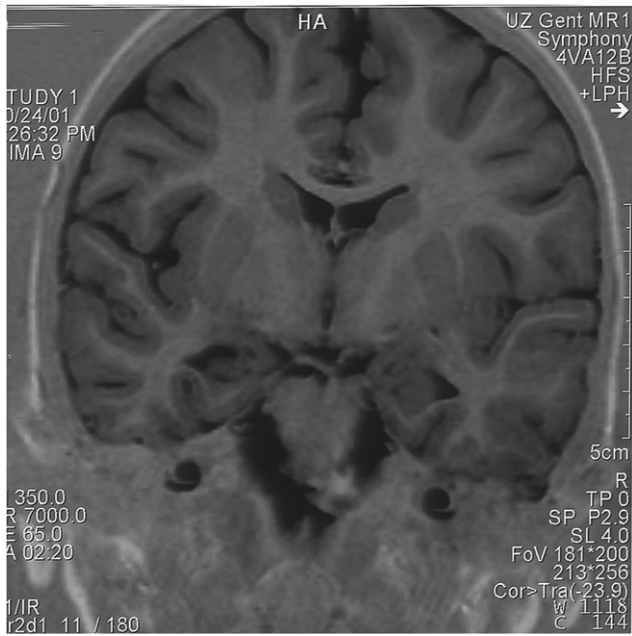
MRI (age 35 months) showing right hippocampal atrophy.
